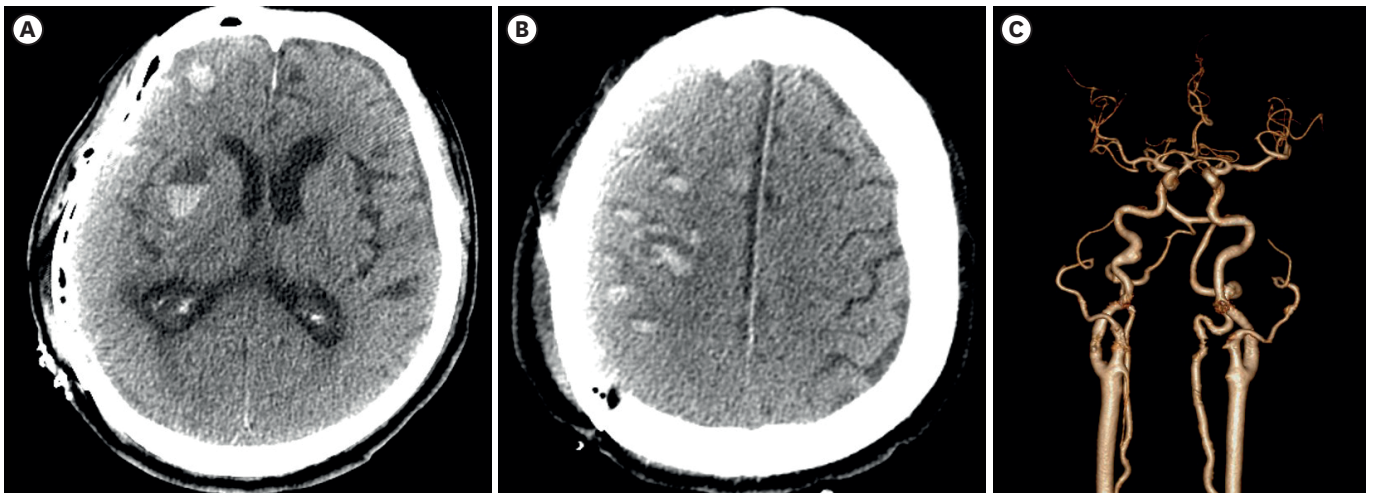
Brain computed tomography after cranioplasty (A-C). Multiple intracranial hemorrhage were confirmed without vascular abnormalities.
